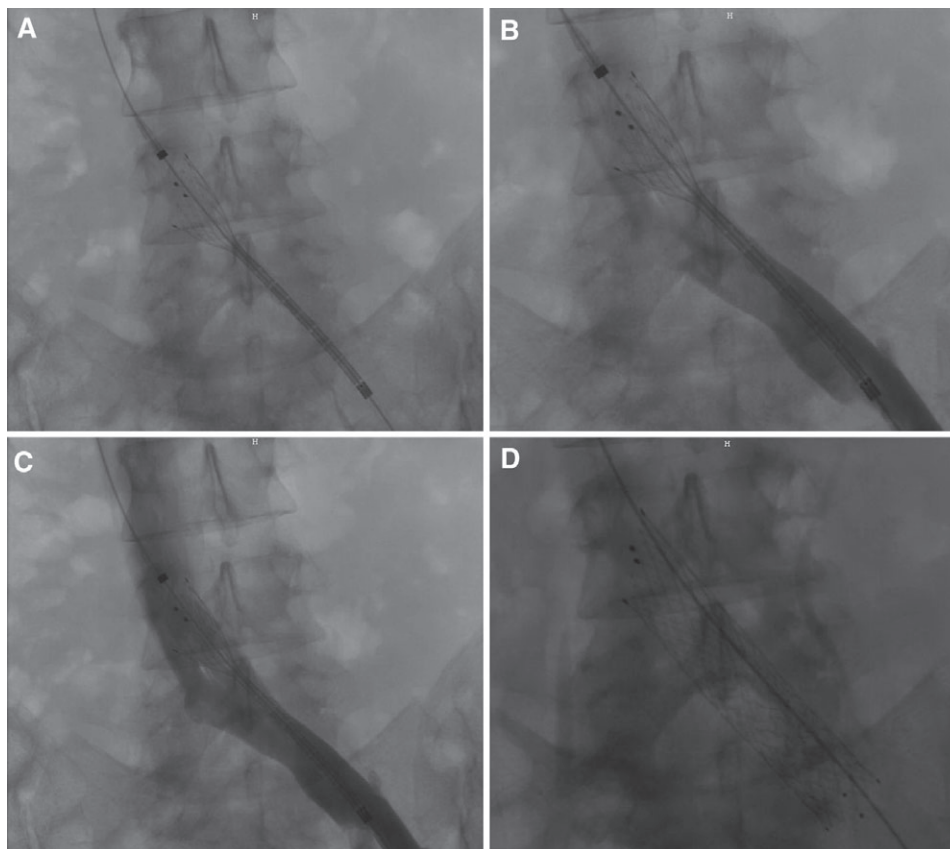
Images showing the preformed intravascular ultrasound (IVUS)-guided percutaneous transluminal angioplasty (PTA) with stenting implantation.
